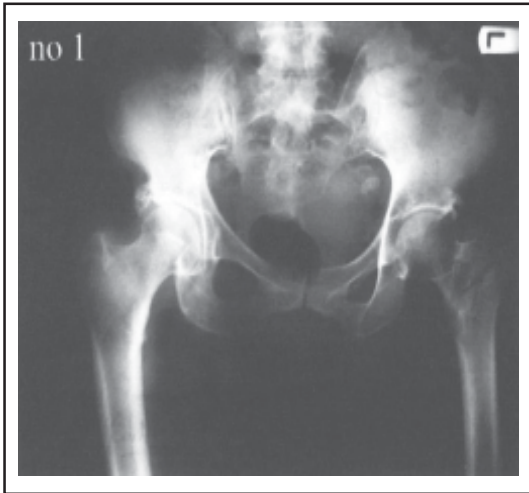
Radiography of a patient before treatment.
